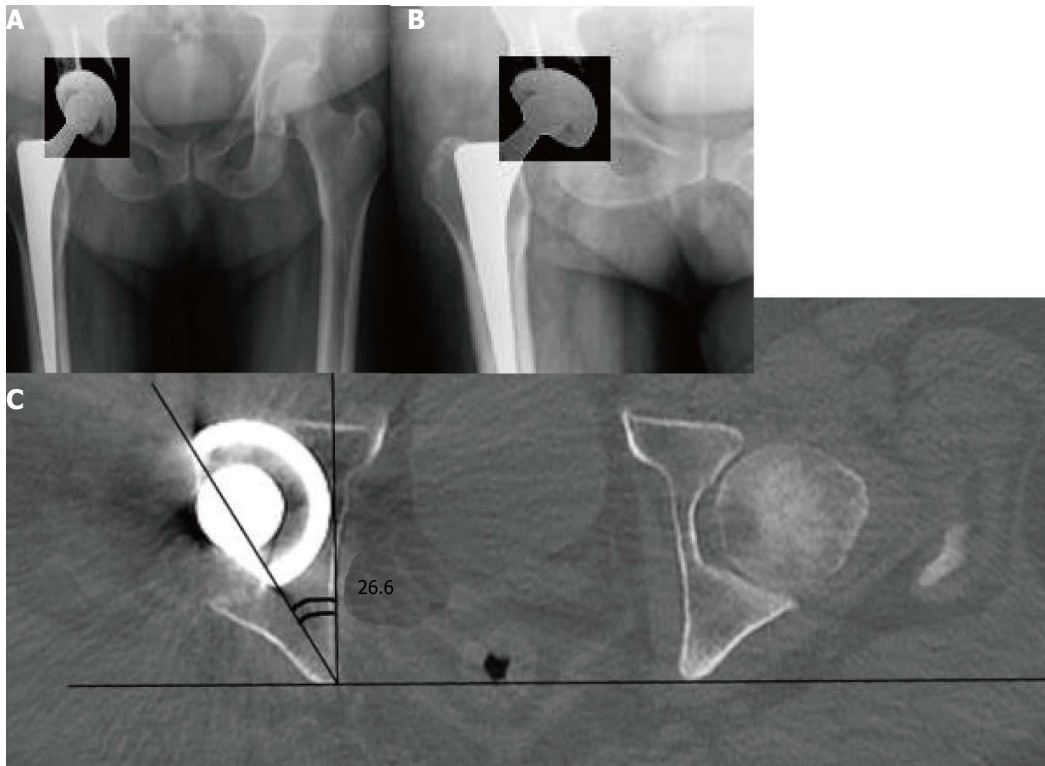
Retroversion sign in a patient with recurrent hip dislocations (enhanced contrasting applied to provide better recognition of acetabular cup ellipse). A: AP Pelvic view; B: AP hip views; C: CT-scan of the same patient confirming acetabular component retroversion. AP: Anteroposterior.
